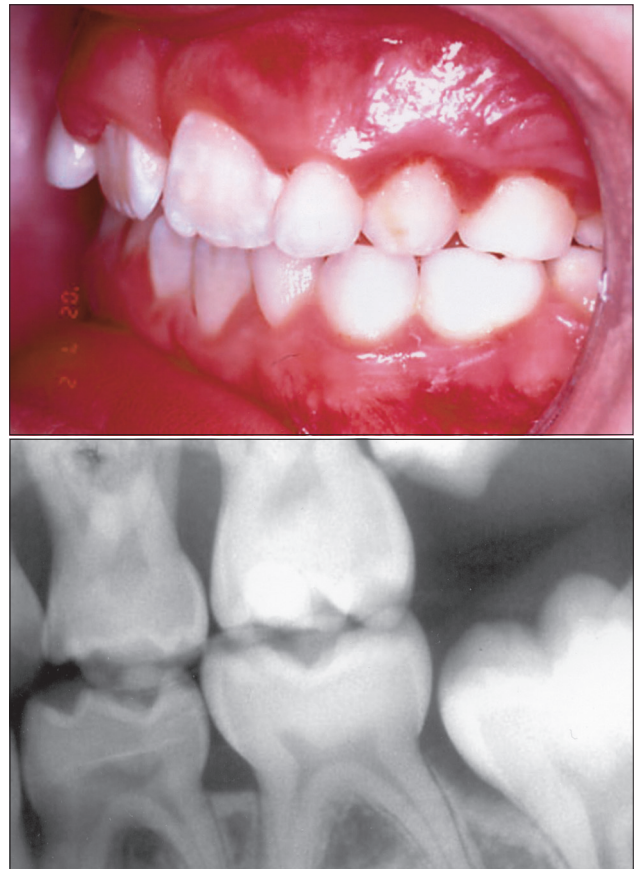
Clinical and radiographic images of case No. 10, 7 years after follow-up of the kindred, and 2 years after the follow-up of the child. Severe gingival inflammation and alveolar bone loss affecting teeth H, I, and J are evident.
